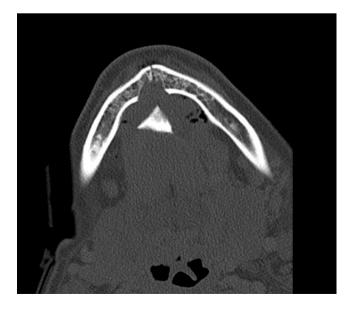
CT image showing the symphyseal fracture with posterior displacement of the geniculate processes. Axial view.
